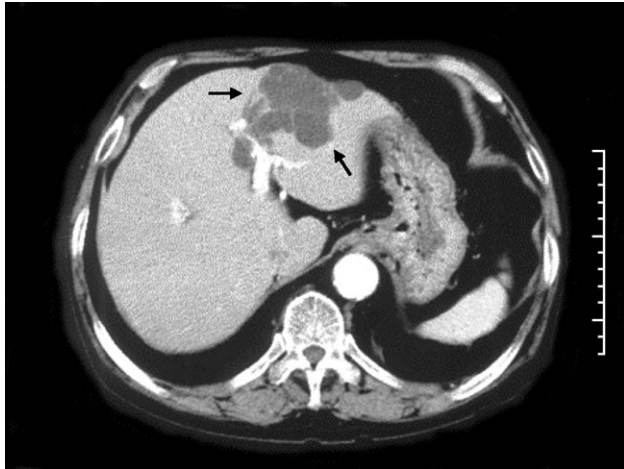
CT shows a multilocular cystic tumor in the left lobe of the liver (arrows). The tumor measures 5 cm in diameter and has no mural modules.
